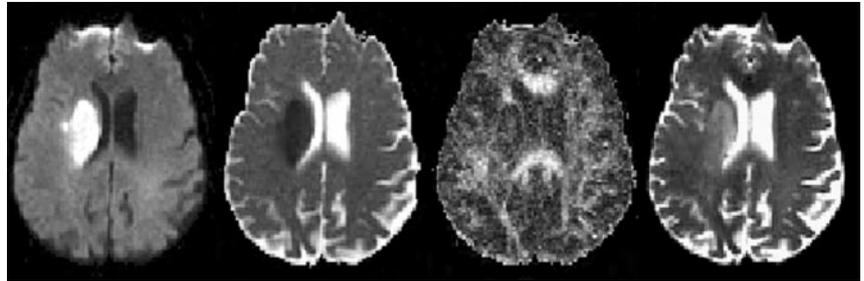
Images in a 71-year-old woman who presented with slurred speech and left-sided weakness and who was imaged 11 hours after the onset of these symptoms. DWI demonstrates an acute infarction involving the right MCA territory. Decreased FA (*far left*) and increased T2 signal intensity (*far right*) was observed in the right corona radiata. This is an example of how decreased FA was associated with increased T2 signal intensity. *Far left*, Isotropic DWI. *Middle left*, ADC map. *Middle right*, FA map. *Far right*, Echo-planar T2WI.
